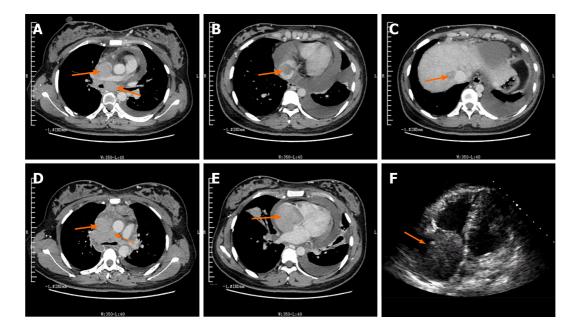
Chest enhanced computed tomography and ultrasonic cardiogram showed extensive thrombi and heart thrombosis. A: Lowdensity filling defect in the superior vena cava; arrow indicate enlarged lymph nodes under the carina of the trachea; B: Low-density filling defect (arrow) at the proximal end of the inferior vena cava; C: Low-density filling defect (arrow) in right hepatic veins; D: Multiple swollen and fused lymph nodes in the anterior trachea; arrow indicates the low-density filling defect in the superior vena cava; E: Low-density filling defect (arrow) in the right atrium; note the lack of infiltration of adjacent structures; F: Cardiac thrombus (arrow) in the right atrium in echocardiography imaging.
